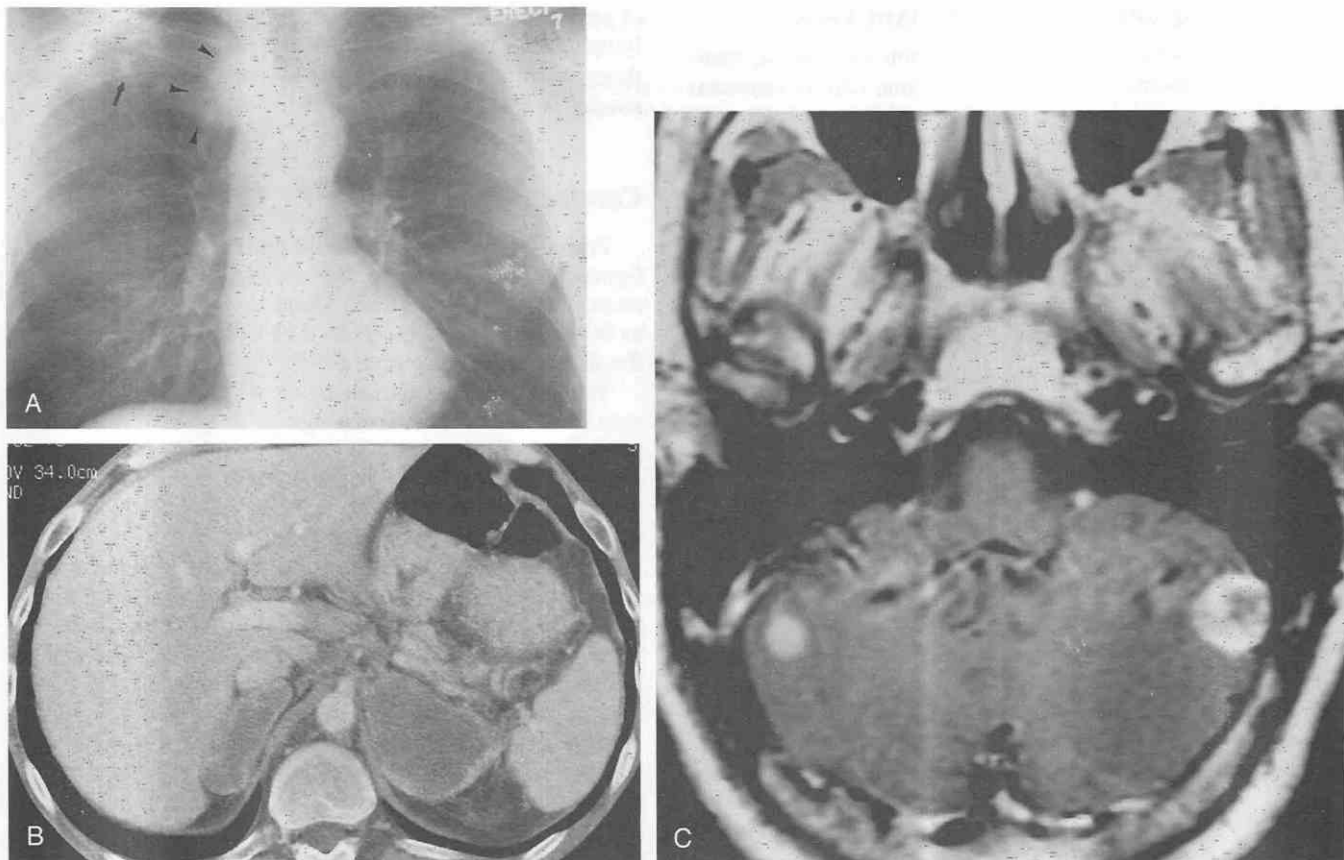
Small-cell lung cancer with disseminated metastases at presentation. A, Posteroanterior chest radiograph shows a poorly margined mass in the right upper lobe (*arrowheads*) and a smaller right upper lobe nodule (*arrow*). B, CT shows large, bilateral necrotic adrenal metastases. C, Axial contrast-enhanced cranial MR image shows enhancing cerebellar metastases.
